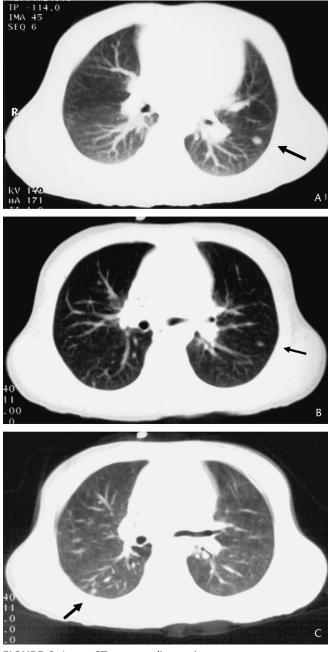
Lung CT scan at diagnosis.
